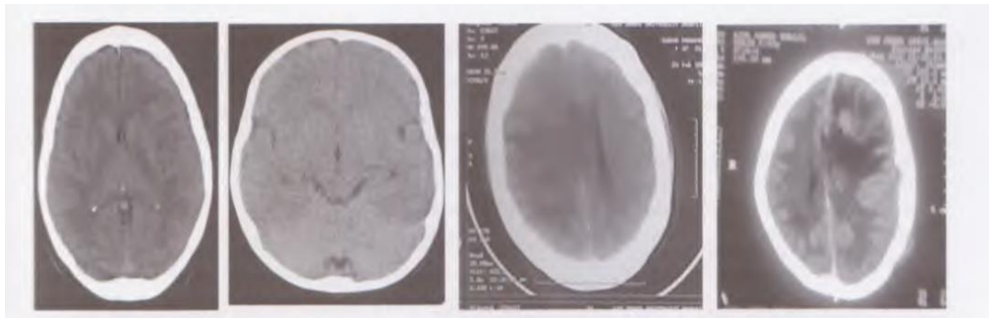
CT SCAN OF THE BRAIN (SPOTLIGHTS IN ANAESTHESIA VOLUME 2)
